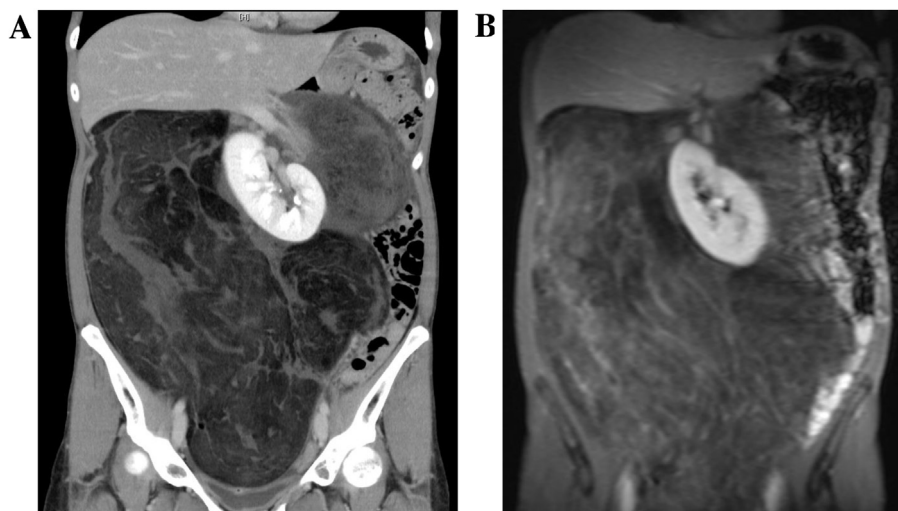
(A) contrast enhanced CT, (B) MRI (fat suppression, T1WI) A 40 × 35 cm solid mass with fat attenuation displacing ascending colon and right kidney to left.
